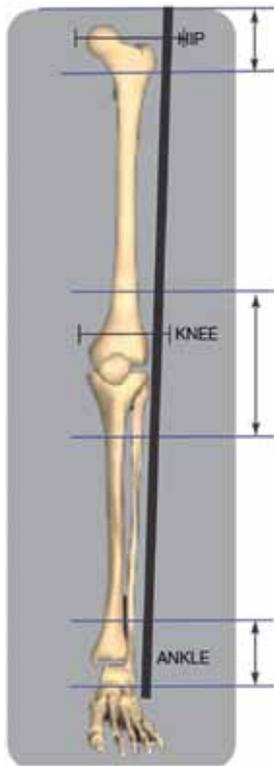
The pre-op CT slices at hip, knee and ankle
